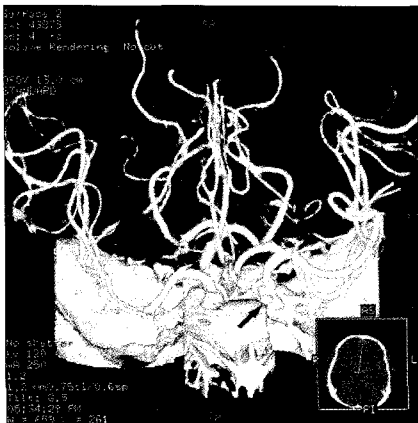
The three dimensional image of multi-slice computed tomography angiogram, demonstrating a suspicious aneurysmal contour at the left paraclinoid area (arrow).
